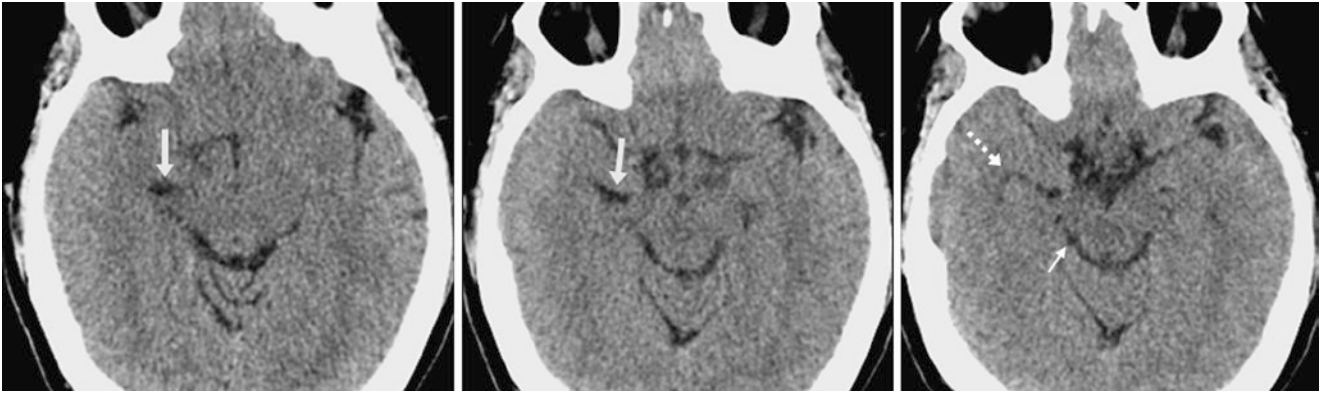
A 48 year old who had multiple images from a routine head CT (which was negative) after a fall. There is asymmetric prominence of the right choroidal fissure (*arrow*). Note the location of the ambient
